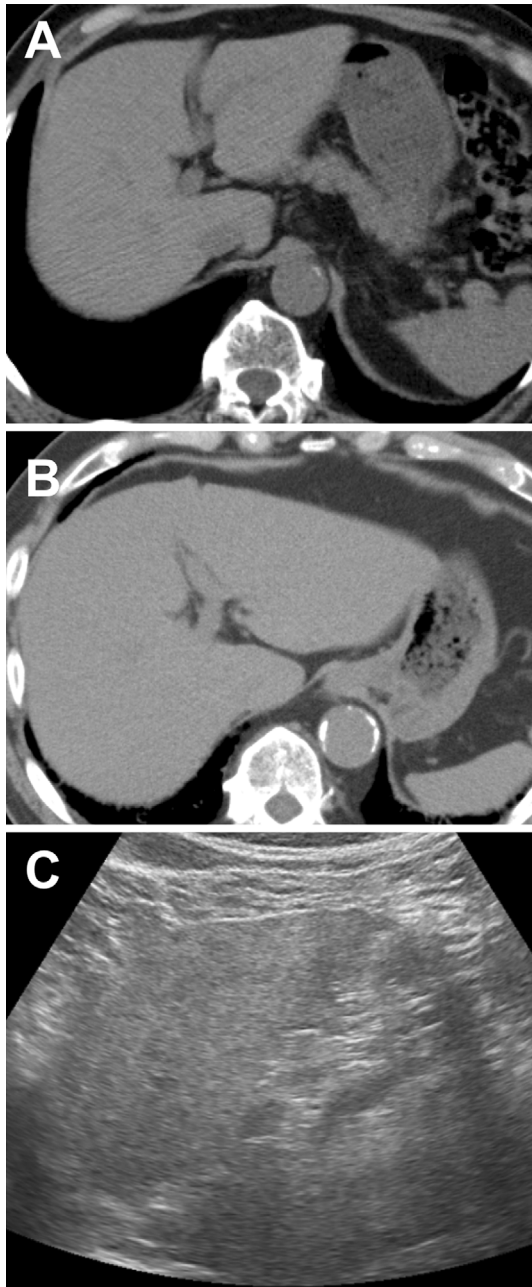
The computed tomography (CT) and ultrasonography findings. The liver/spleen (L/S) ratio, as determined by CT, was lower than that before R-DeVIC therapy. Ultrasonography revealed an increase in echogenicity in the liver. A: CT scans performed during the precontrast phase when the patient underwent R-DeVIC therapy (L/S ratio: 2.8). B: A CT scan during the precontrast phase when he was referred to our department (L/S ratio: 1.1). C: Ultrasonography of liver.
